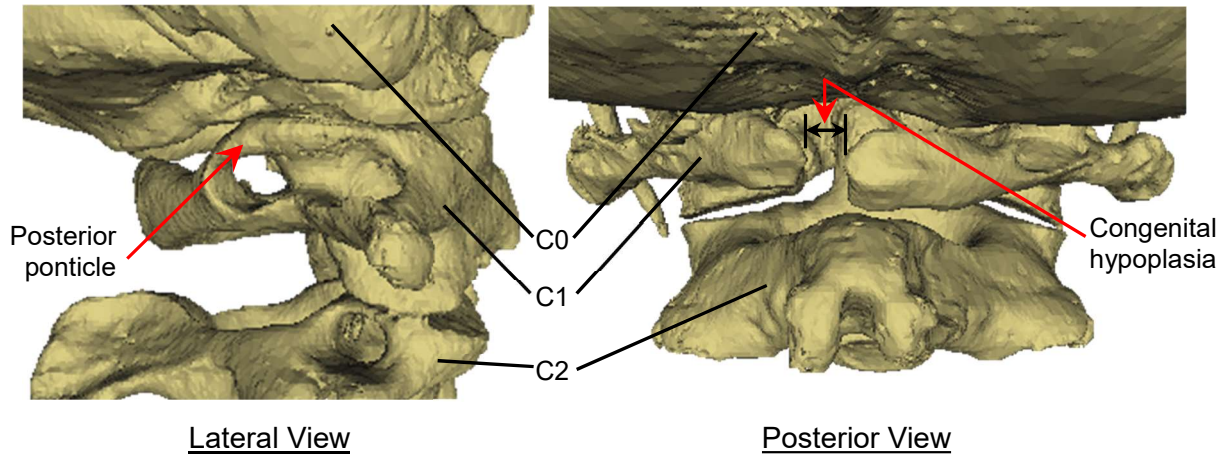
3D models created from CT scans showing anomalies: unilateral posterior ponticle (left) and congenital hypoplasia of C1 arch (right)
